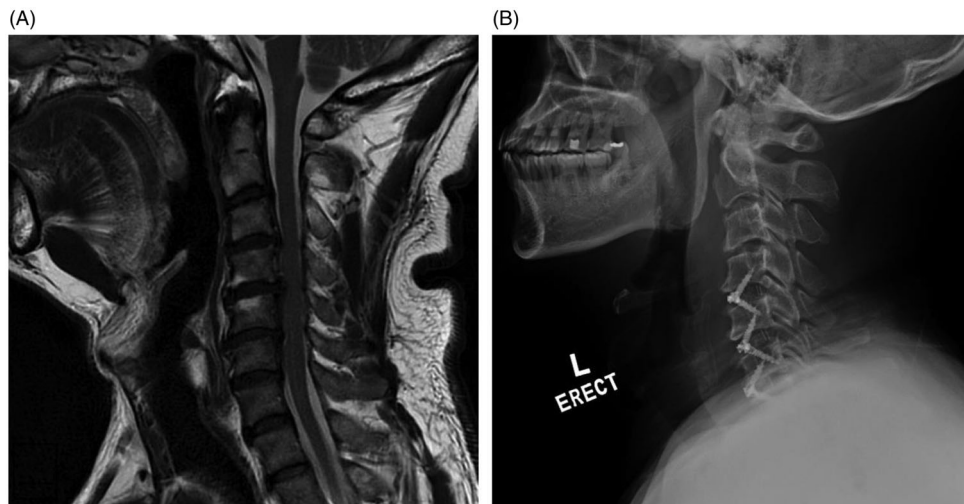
Plain lateral radiograph of the cervical spine of a 61-year-old man who had undergone C4/5 C5/6 C6/7 anterior cervical diskectomy and fusion (ACDF). He was kept intubated to the ICU after the operation. As compared to the preoperative magnetic resonance image (MRI) scan (A), the postoperative day 1 radiograph (B) had shown significant pre-vertebral swelling. He was extubated in the ICU the same day on post-op Day 0. He had transient hoarseness of voice but no airway obstruction. His length of stay in the ICU was one day and was discharged home the next day on post-op Day 1. His symptoms including hoarseness of voice completely resolved in one week.
